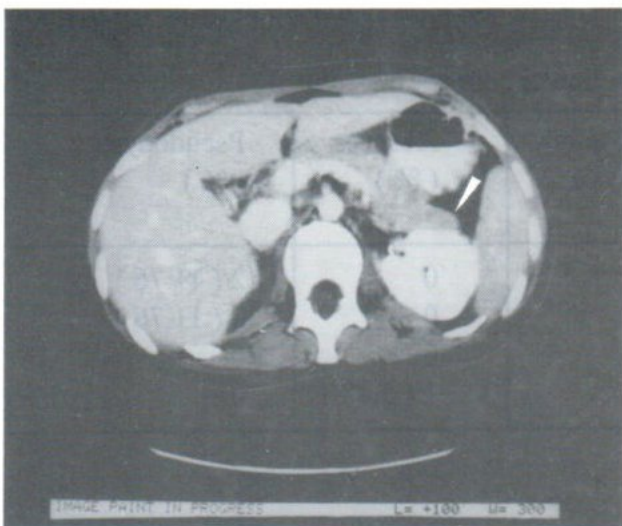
CT study demonstrating a normal pancreas in a patient with clinical pancreatitis (grade A).
